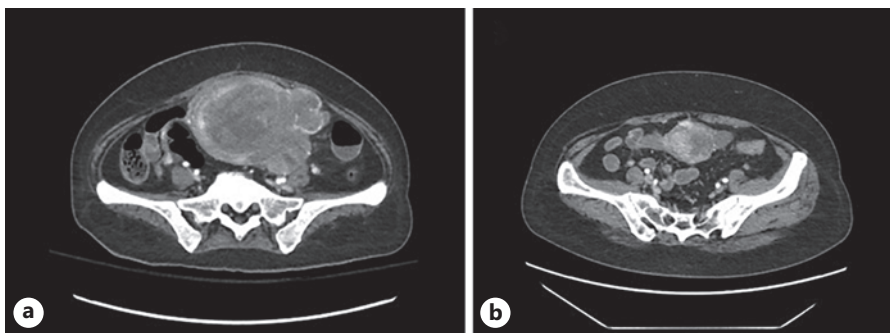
CT evaluation of uterine mass. From left to right: (a) prior to the start of pembrolizumab (13.1 × 7.5 × 14.8 cm), (b) after 12 cycles of pembrolizumab (4.7 × 2.4 × 2.4 cm).
